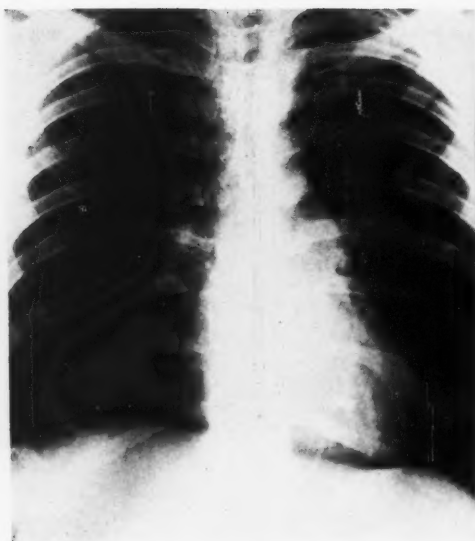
Left.* Case 6. Postero-anterior chest roentgenogram demonstrating retained shell fragment in the myocardium.
